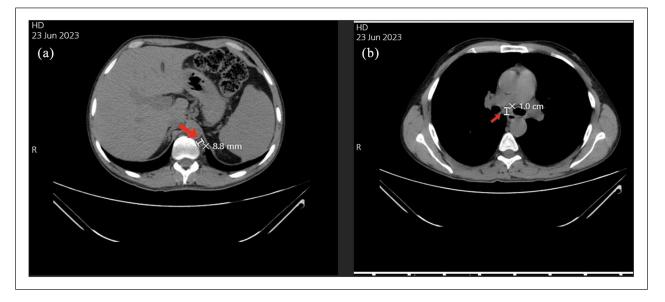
(a) Chest CT scan without contrast showed subcrural lymph node enlargement suspect Hodgkin lymphoma. (b) Chest CT scan without contrast showed para-aortic lymph node enlargement suspect Hodgkin lymphoma.
